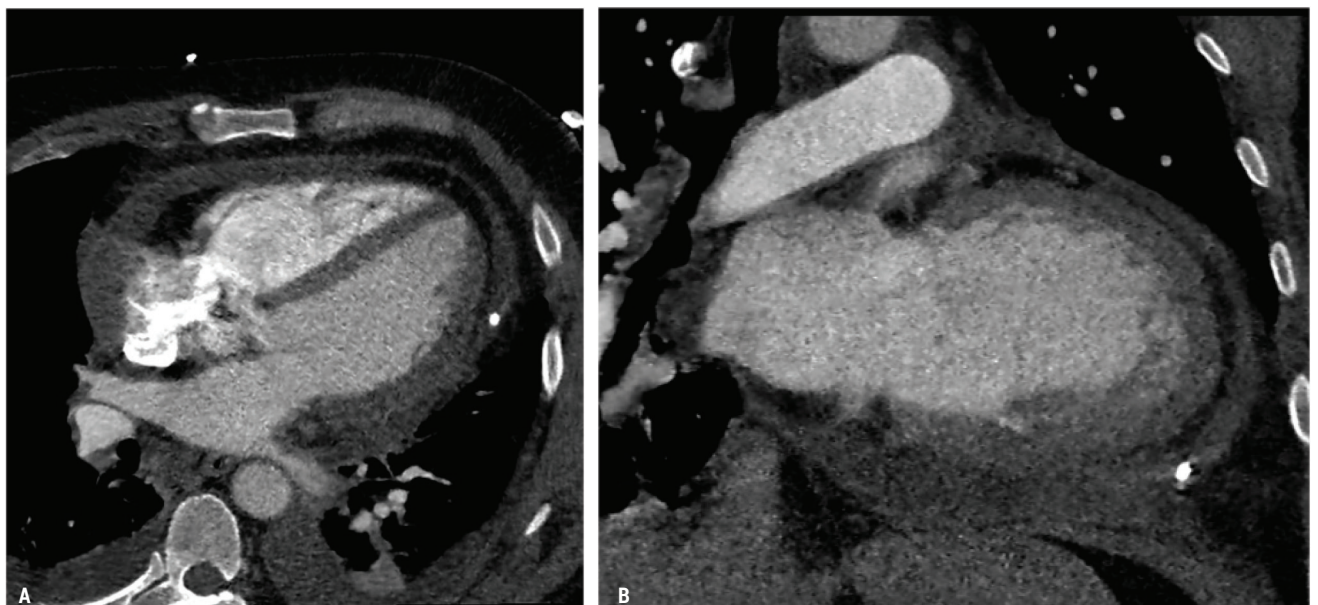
Cardiac CT with flattened septum and pericardial effusion. A) Four chamber view, B) long axis; *drainage catheter in the pericardium.
